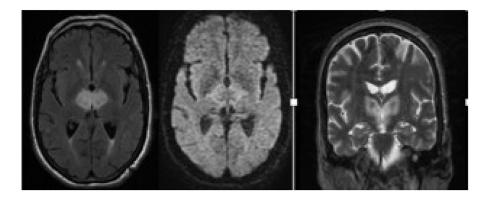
MRI in axial sections, flair, diffusion, and T2 sequences showing the presence of 2 moderate thalamic lesions, extended to the right midbrain, well limited in rounded shape, described in T2 and flair hypersignal, with a restrictive shell in diffusion.
